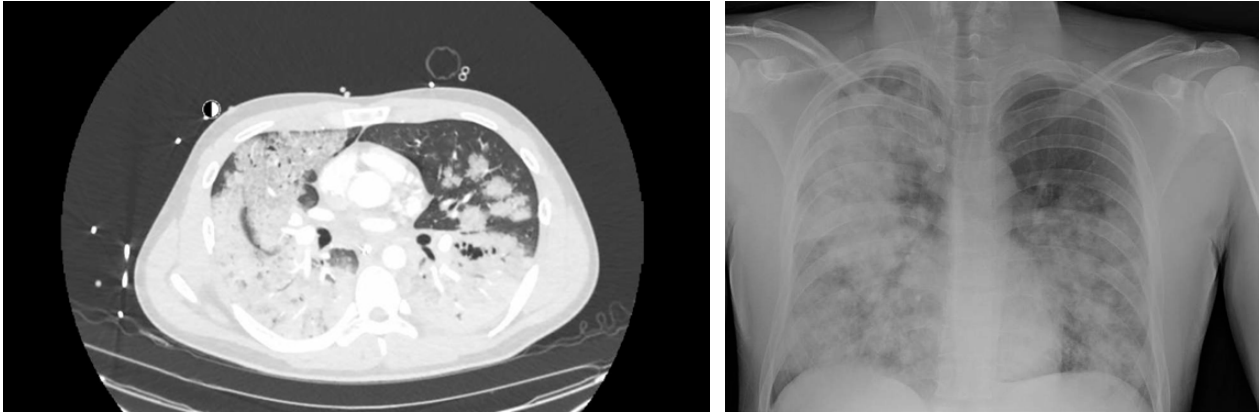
Chest radiograph and contrast-enhanced chest computed tomography, lung window, at the time of patient admission.
